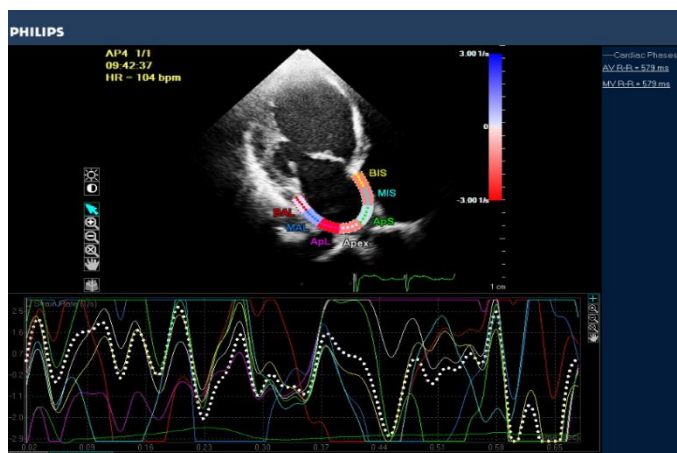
Two-dimensional echocardiography showing peak LA strain rate in normal control subject (strain rate 2.5 s^{-1}).
